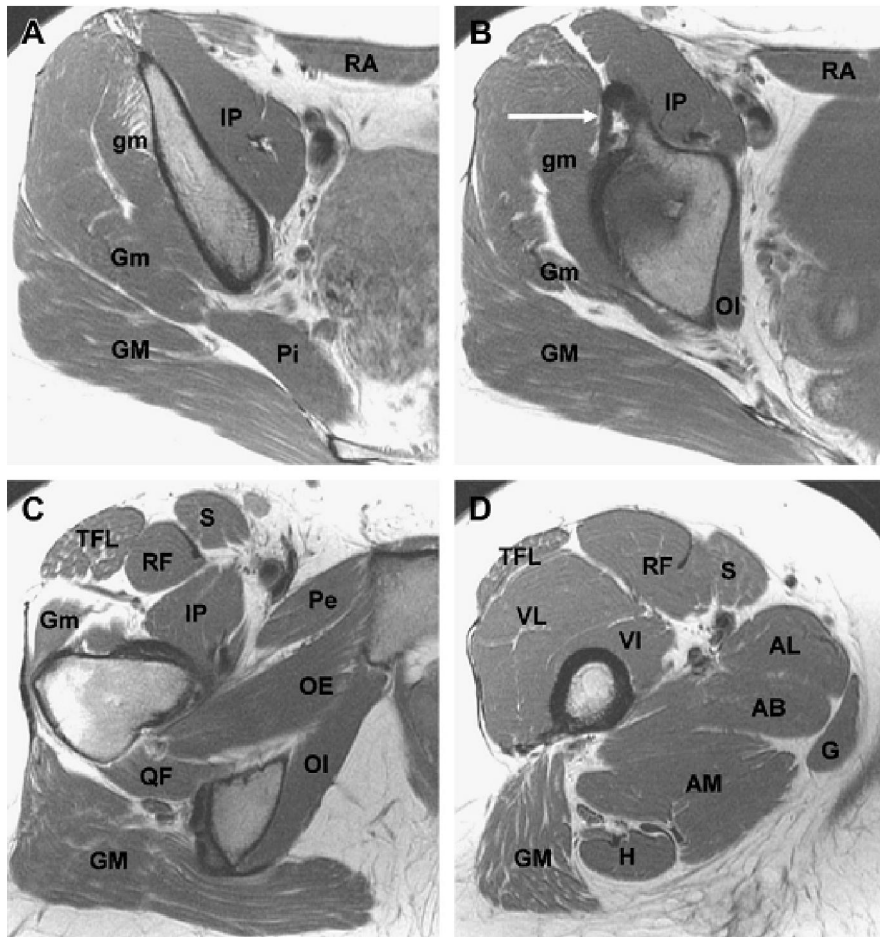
(A–D) axial proton density weighted MR images from superior to inferior demonstrate: AB, adductor brevis; AL, adductor longus; AM, adductor magnus; G, gracilis; gm, gluteus minimus; Gm, gluteus medius; GM, gluteus maximus; H, hamstrings; IP, iliopsoas; OE, obturator externus; OI, obturator internus; Pe, pectineus; Pi, piriformis; QF, quadratus femoris; RA, rectus abdominis; RF, rectus femoris; S, sartorius; TFL, tensor fascia lata; VI, vastus intermedius; VL, vastus lateralis. (B) Reflected head of the rectus femoris (arrow), which attaches to the superolateral aspect of the acetabulum (connie and Ambrose, 2013).
